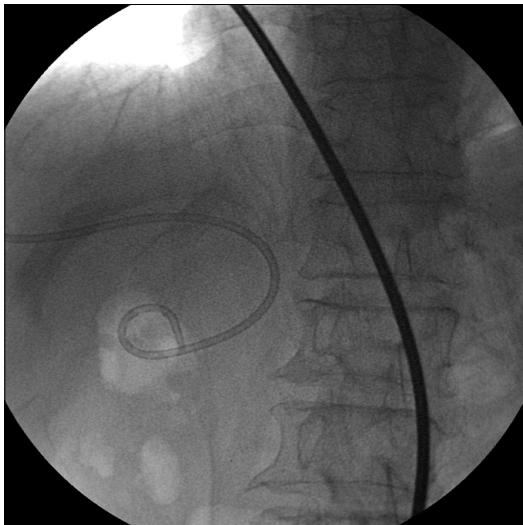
A pigtail catheter was inserted into the cyst under ultrasound guidance.
